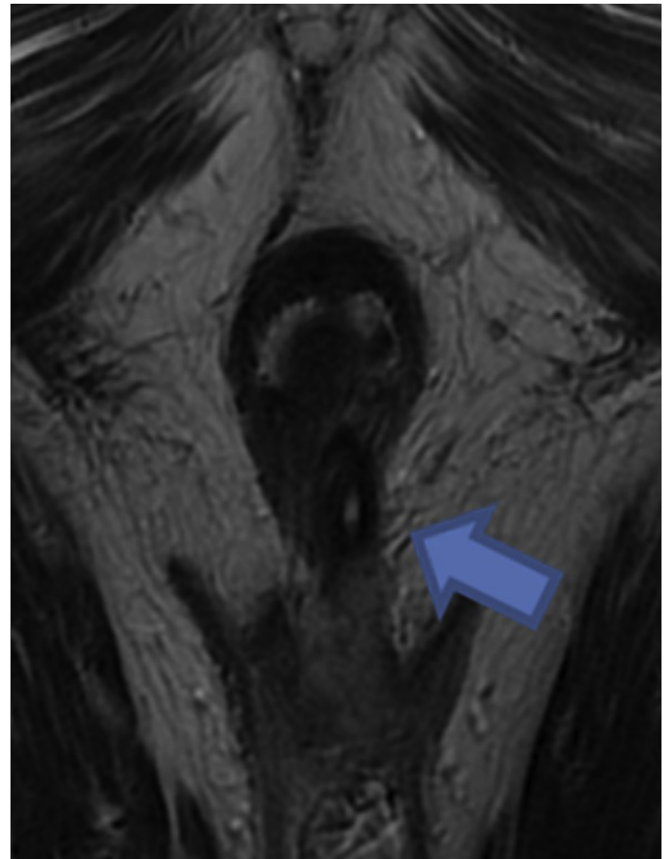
Sequential coronal sections on MRI showing a fistulous tract (Arrows).
